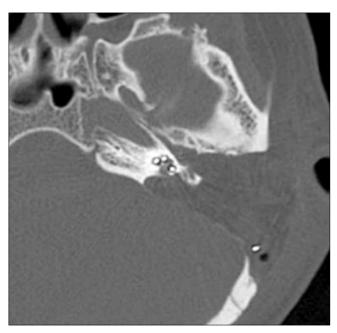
Post-operative CT scan confirms the correct position of the array. The surgical cavity is filled with abdominal fat.
